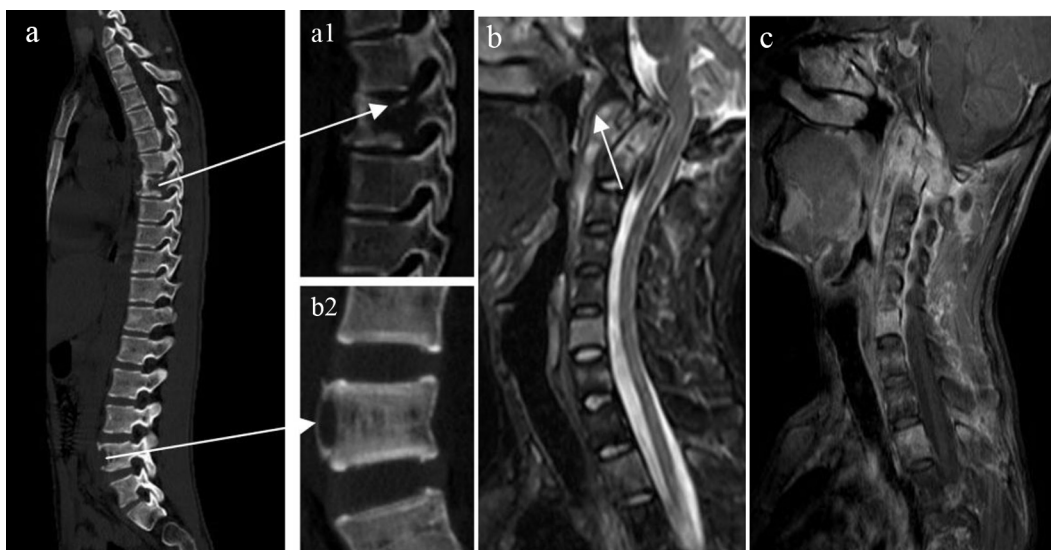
Imaging of the 16-year-old male patient revealed T7 and L4 with multiple bone destruction (Fig. 5a, Fig. 5a1 and a2 were enlarged views of lesions). (b) Sagittal T2WI MRI showed paravertebral soft tissue (white arrow). (c) Sagittal enhanced T1WI signified obvious enhancement.
